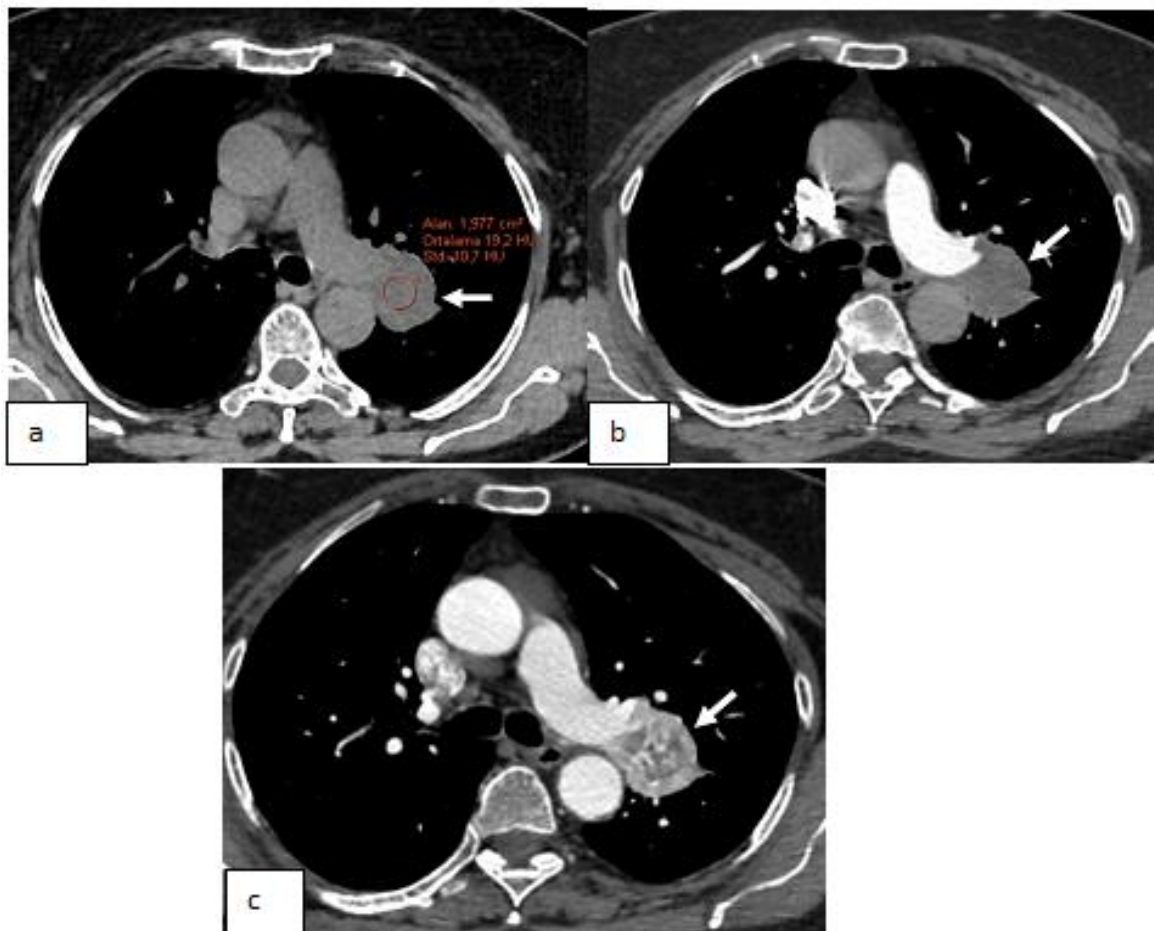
Axial precontrast CT image and b,c Axial Pulmonary CTA images showing a well-defined middle mediastinal mass between left pulmonary artery and the descending aorta with intermediate soft tissue density on precontrast (a, arrow) without any calcifications and pulmonary arterial phase images (b, arrow) without enhancement. Heterogeneously intense enhancement on early arterial phase images with multiple serpentine tortuous tubular enhancing vasculature within the lesion is demonstrated (c, arrow).
